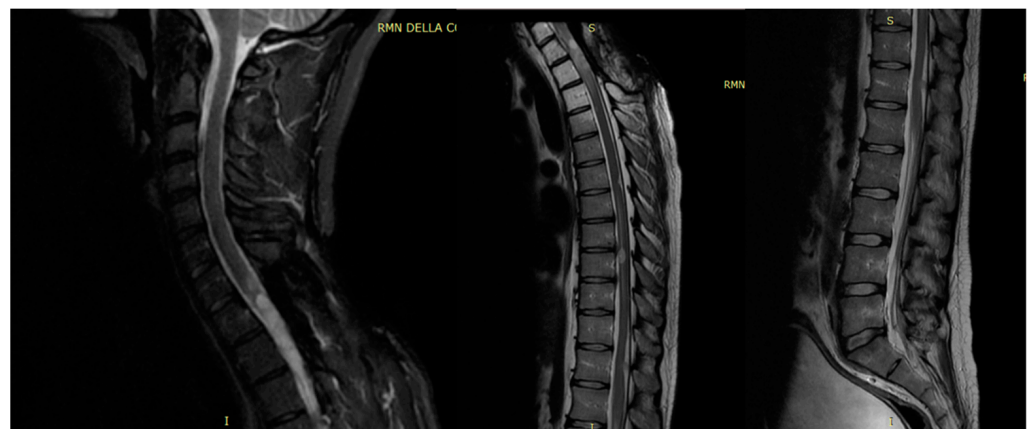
Follow-up spine MRI with disease progression in T2 sagittal view of the cervical, thoracic, and lumbar tracts after adjuvant therapy.
